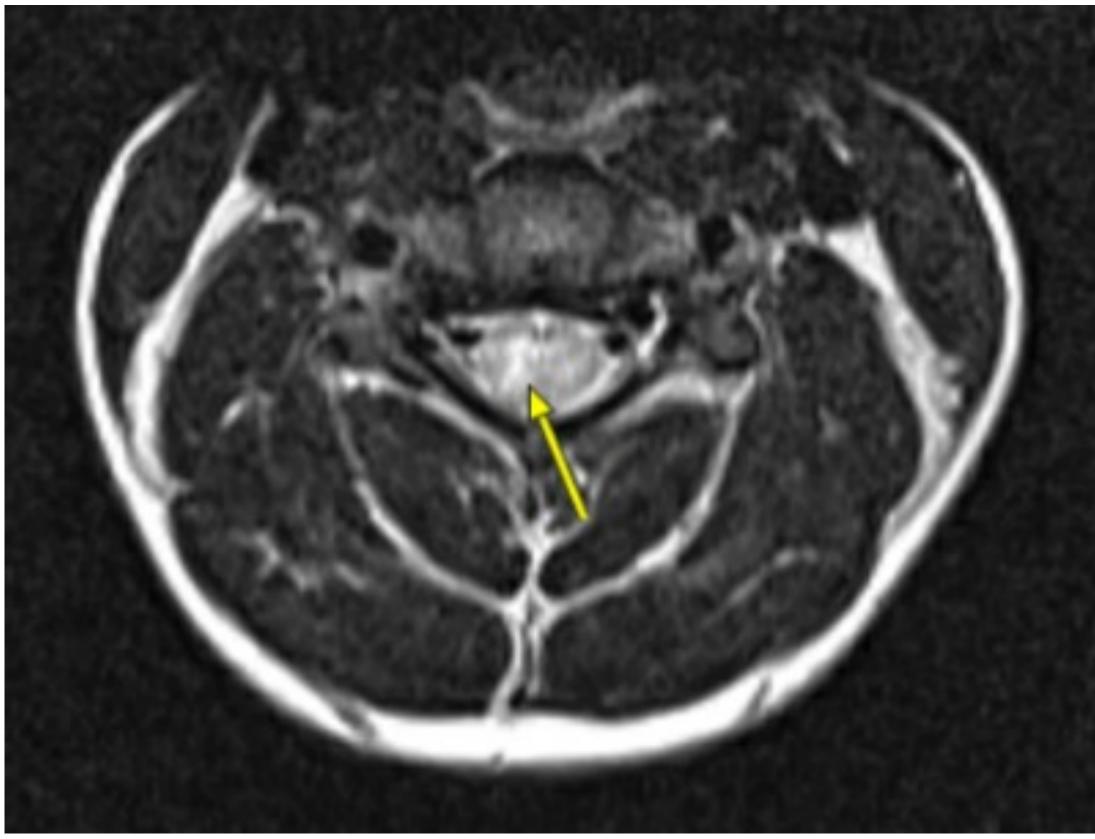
T2 Stir MRI of cervical spine axial showing lateralization at the level of C4-C6.
